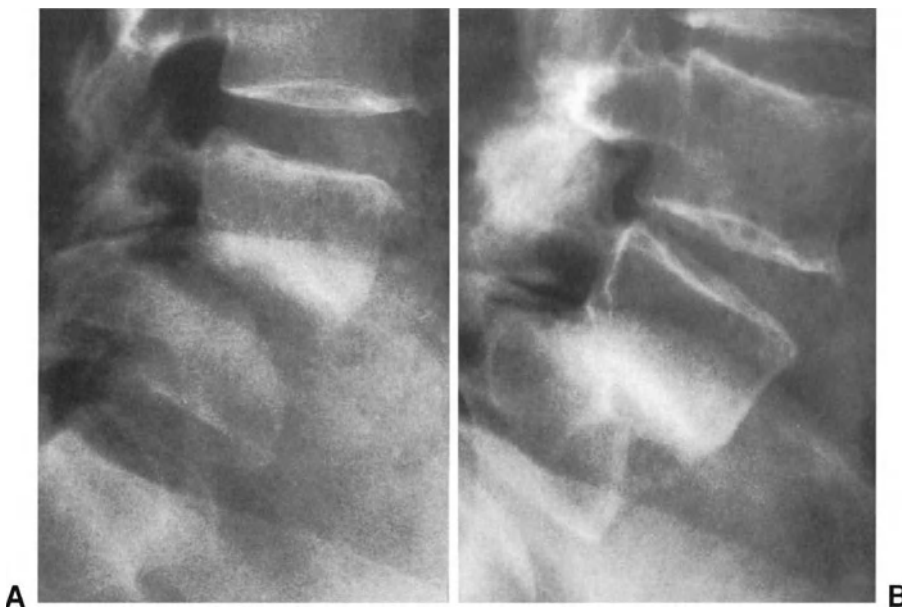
Patient with spondylodiscitis following L4-L5 laminectomy and posterolateral fusion due to degenerative spondylolisthesis of L4. Three months after the operation (A), the radiograph revealed a marked destruction of the anterosuperior aspect of the L5 vertebral body. Sixteen months after surgery (B), a collapse of the L4-L5 disc had occurred leading to spontaneous interbody fusion and segmental kyphosis.
